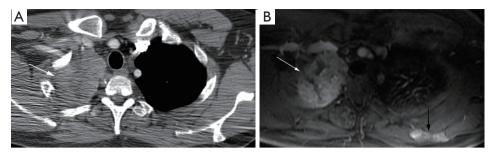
Forty-two-year-old man with chest pain, and a prevascular mediastinal mass biopsy-proven as thymic carcinoma (not shown). (A) Contrast-enhanced chest CT demonstrates concentric right pleural nodular thickening (arrow) consistent with pleural metastatic disease; (B) an axial T1-weighted fast spin echo with fat saturation MRI after administration of paramagnetic intravenous contrast, performed few days following the CT, shows the right circumferential pleural metastatic disease (white arrow). In addition, an enhancing left scapular lesion (black arrow) is seen, not easily identified on the CT, and is consistent with a bone metastasis. MRI is a valuable tool in the assessment of the chest wall and soft tissues due to its better contrast resolution when compared with CT. CT, computed tomography; MRI, magnetic resonance imaging.
